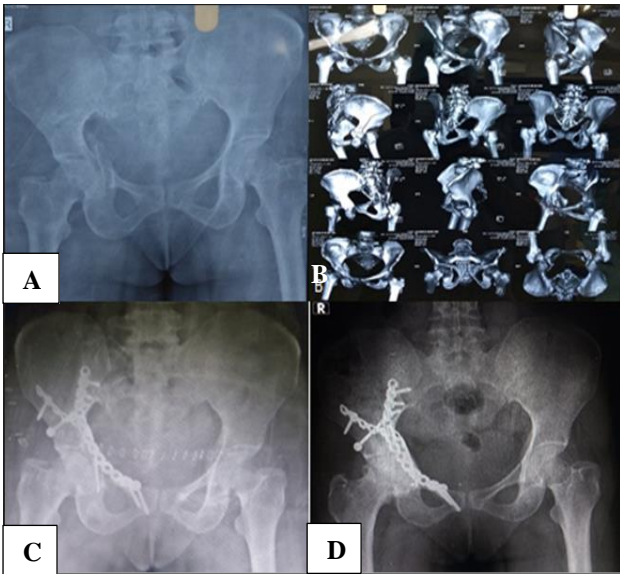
40-year-old female right sided ACPHT fracture (A) pre-op X-ray; (B) pre-op CT scan; (C) immediate post-op X-ray; and (D) 6 months' post-op X-ray.
